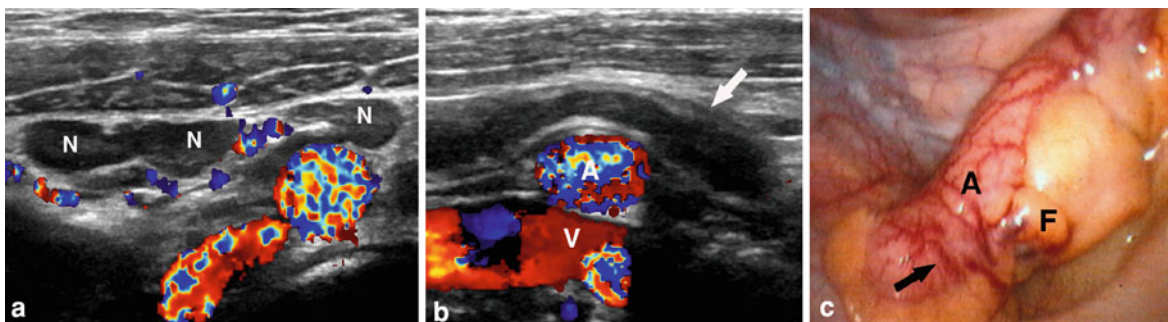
a, b, c Appendicitis associated with enlarged mesenteric lymph nodes in young adult. In a, color Doppler sonogram demonstrates multiple enlarged mesenteric nodes (“N”). In b, note enlarged appendix with distended fluid-filled lumen (arrow) draped over external iliac artery (“A”) and vein (“V”). Note that echogenic submucosal layer of appendix is
